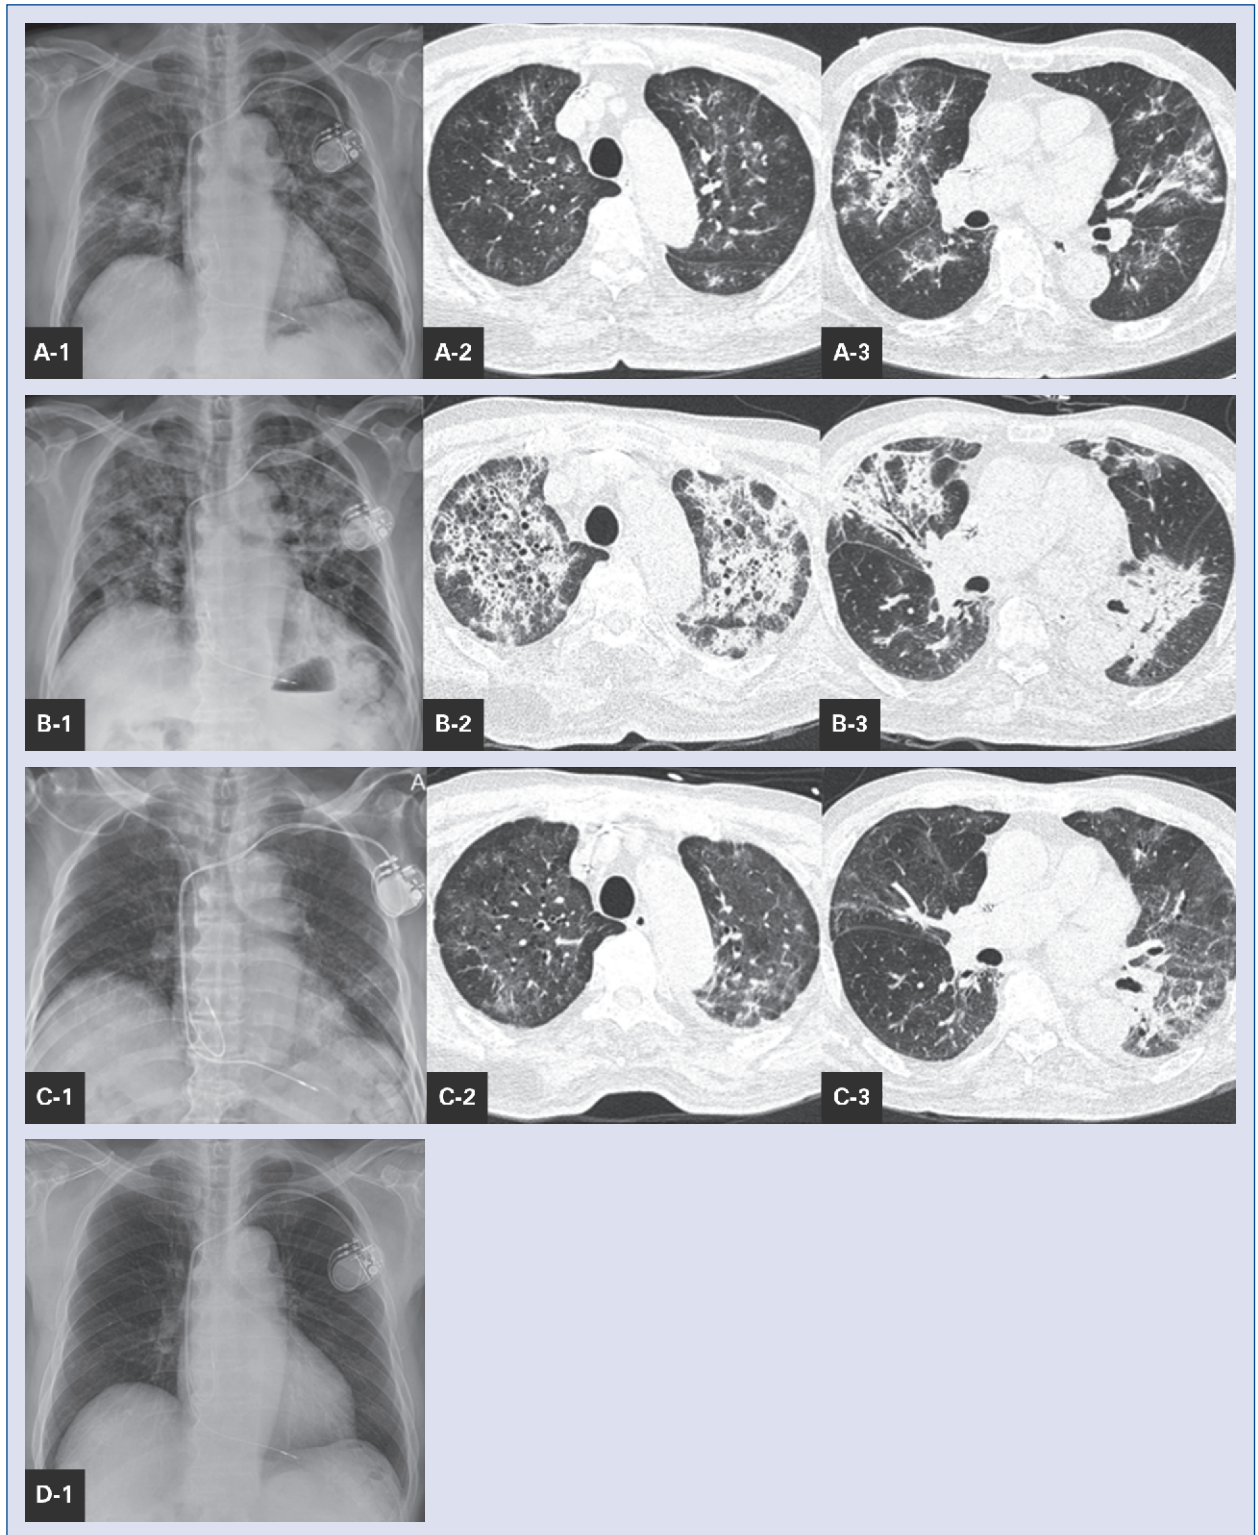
A. Chest X-ray and high-resolution computed tomography (HRCT) findings from the first medical examination; B. Follow-up chest X-ray and HRCT findings obtained 2 weeks later; C. Follow-up chest X-ray and HRCT findings obtained after withdrawal of apixaban and pulse therapy with methylprednisolone; D. Follow-up chest X-ray obtained 1 month later showed a complete recovery.
